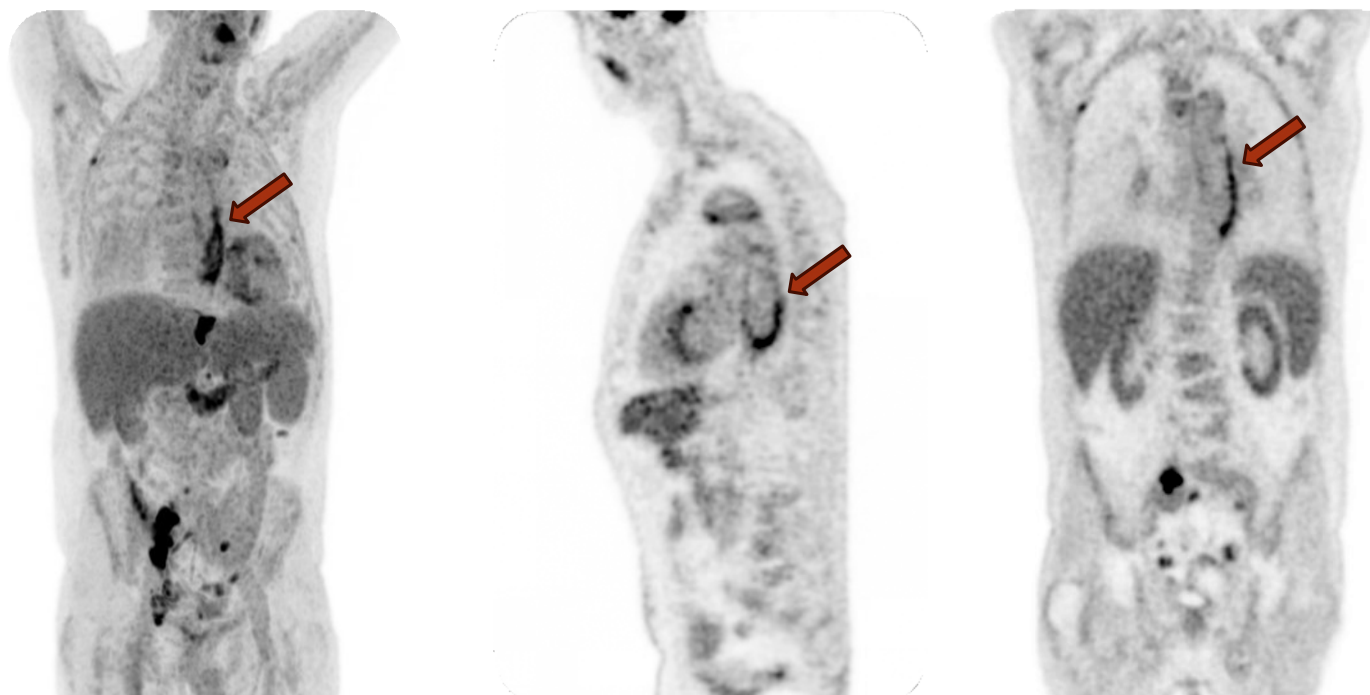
[¹⁸F] FDG PET-CT: Thickening of the thoracic aorta compatible with the diagnosis of aortitis.
